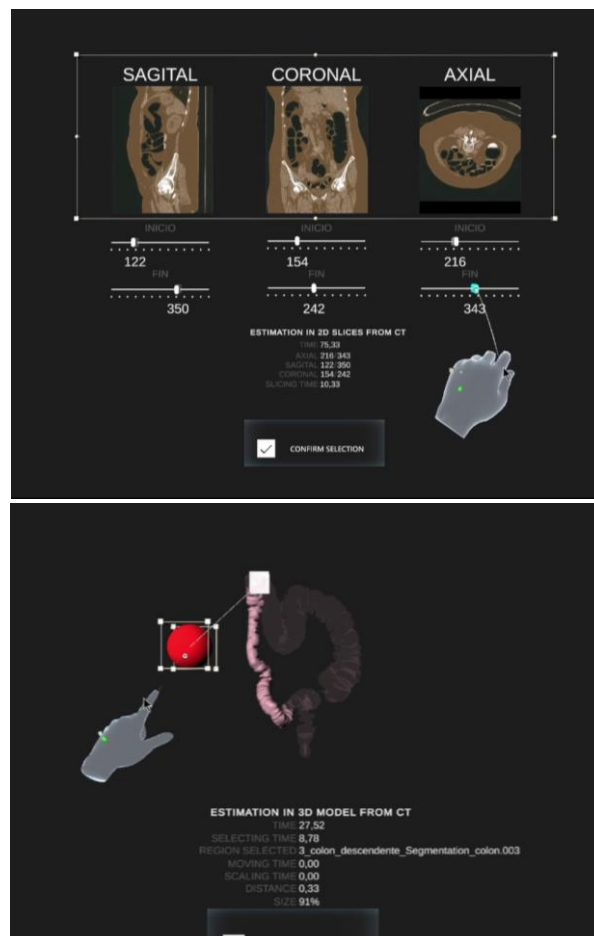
MR application for colon anatomy training and lesion identification by medical imaging. On the left is shown the environment based on navigation in CT slices and on the right the identification of lesions in 3D holographic models.
